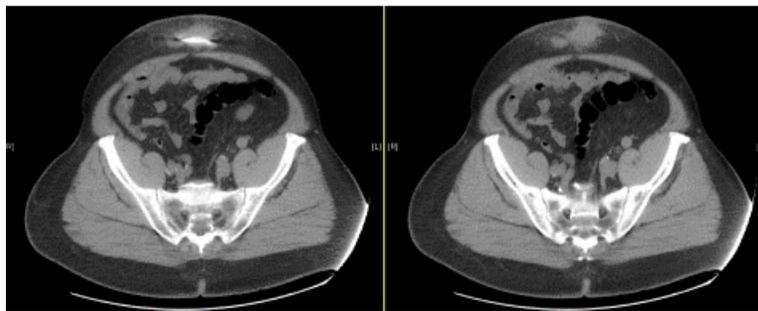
CT scan of the abdomen without contrast that depicts an infraumbilical abscess localized to the driveline.
